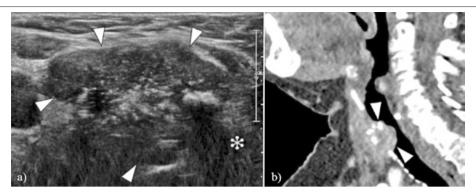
Papillary thyroid carcinoma (arrowheads) that at the time of the study with ultrasound (a) presented an extension towards the trachea (asterisk), difficult to characterize; b) CT of the same patient better demonstrates the tracheal invasion (arrow heads). Asterisk: trachea.
